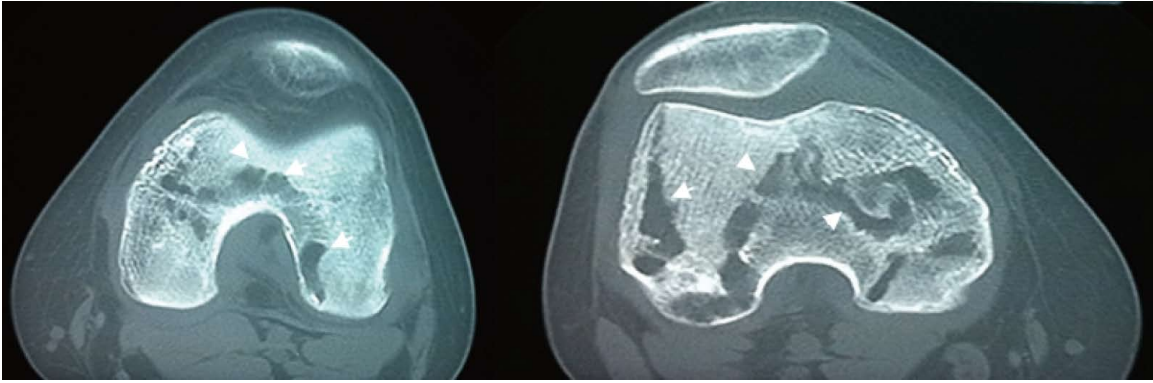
Computed tomography showing multiple lacunar areas in the femurs and patellas.
